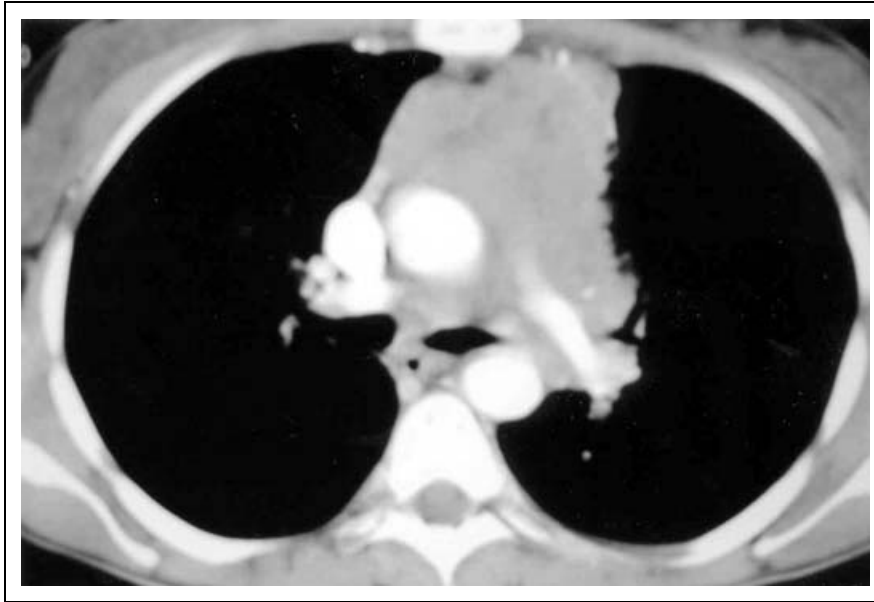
Chest CT scan, revealing a large solid mass in the superior aspect of the mediastinum surrounding supra-aortic vessels and lung hilus.
